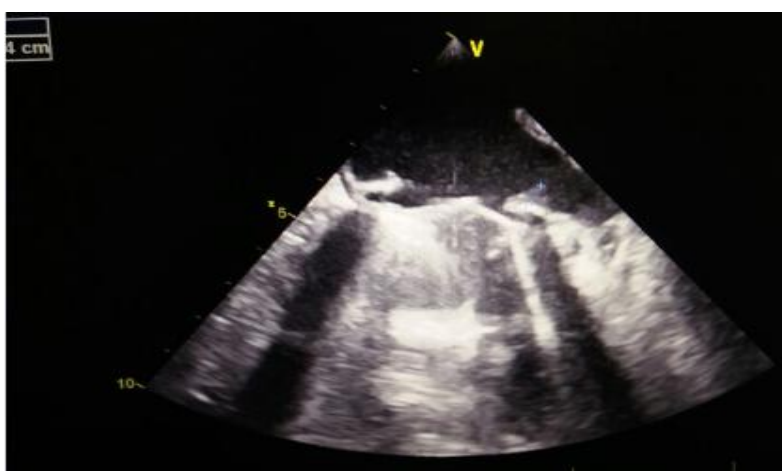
Transesophageal echocardiography performed after adjustment of the anticoagulant treatment showed a disappearance of the thrombus with persistence of a small element of 4 mm
